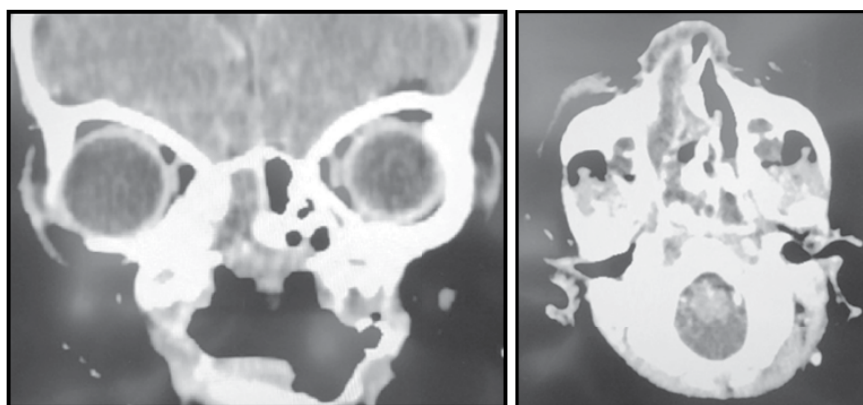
Contrast enhanced CT of nose and paranasal sinuses shows the tumour; A. Coronal view, B. Axial view.
